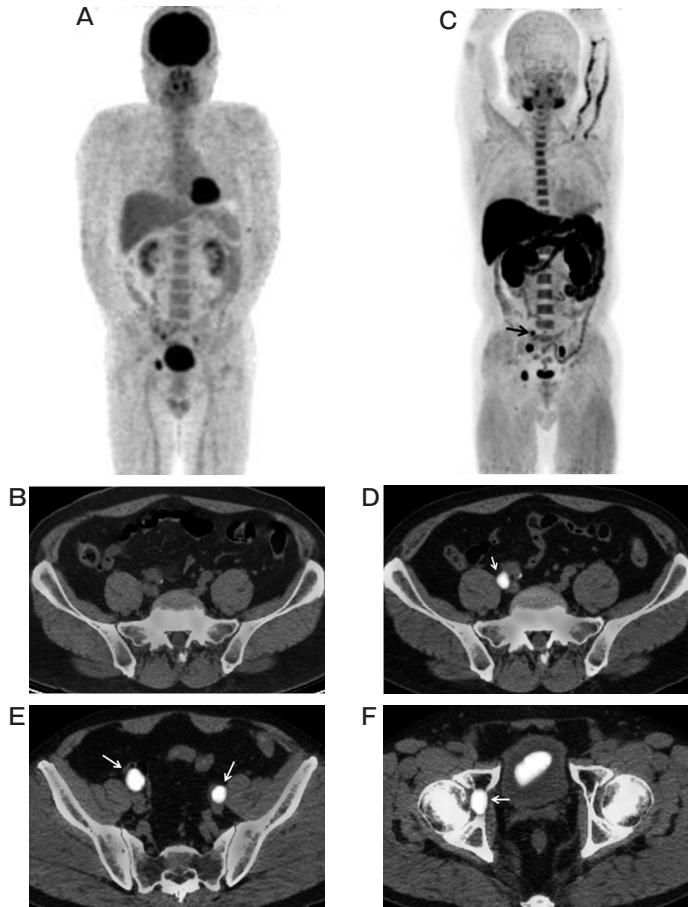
A 66-year-old man with a PSA level of 4.68 ng/mL who underwent radiotherapy and androgen-deprivation therapy for prostate cancer (cT4N0M0, initial PSA 79.5 ng/mL), in whom pelvic node and bone metastasis was found. A, MIP from FDG PET showing three abnormal FDG uptake spots in the pelvis; B, FDG-PET/CT image showing no abnormal findings at the same level as panel D below; C, MIP from ^{11}C -choline PET showing four abnormal ^{11}C -choline uptake spots in the pelvis, including the right internal iliac area (*arrow*); D, ^{11}C -choline PET/CT image showing strong ^{11}C -choline uptake (SUVmax 6.35) in the right 6-mm internal iliac node (*arrow*), suggesting lymph node metastasis; E, ^{11}C -choline PET/CT image showing strong ^{11}C -choline uptake in the right 14-mm external iliac (SUVmax 13.90) and left 8-mm external iliac (SUVmax 9.01) nodes (*arrows*), reflecting lymph node metastasis; F, ^{11}C -choline PET/CT image showing strong ^{11}C -choline uptake (SUVmax 11.77) in the right acetabular cartilage (*arrow*), reflecting bone metastasis.
